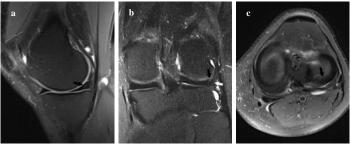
a-c: Sagittal PDW Fat Sat 3.0 T MRI image shows diffuse signal extended to no surface area of lateral meniscus posterior horn (arrow, a). Coronal T2W Fat Sat 3.0 T MRI image shows very small extrameniscal signal adjacent to lateral meniscus posterior horn (black arrow, b) due to the effusion between the popliteus muscle tendon (white arrow, b) and meniscus. There is no signal in lateral meniscus posterior horn in axial PDW Fat Sat 3.0 T MRI image (arrow, c).
